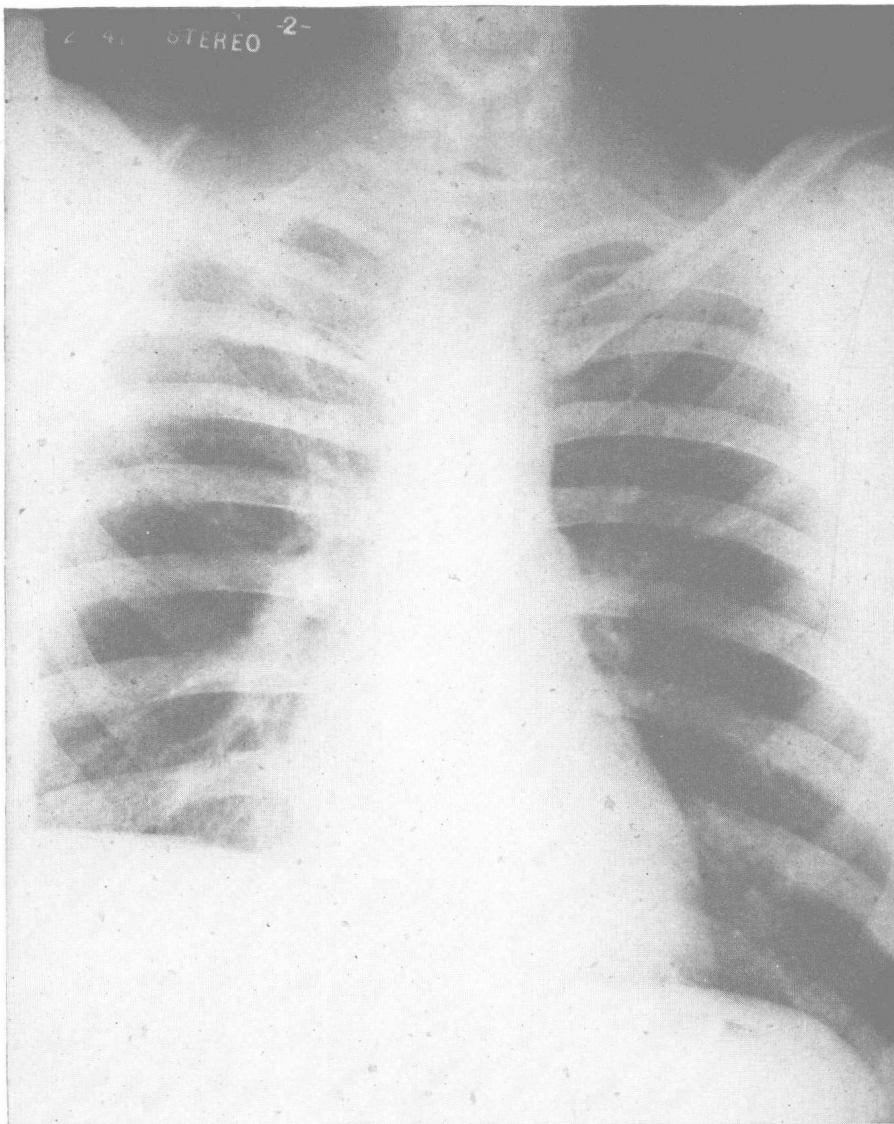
On the roentgenogram follow-up December 2, 1941, the right diaphragm was elevated, the cavity outlines had disappeared and there was increasing fibrosis in the right apex. The fluoroscopic examination showed paradoxical movement of the right hemidiaphragm. He was symptom-free and a small amount of sputum and gastric washings showed no tubercle bacilli. His disease has become quiescent.
